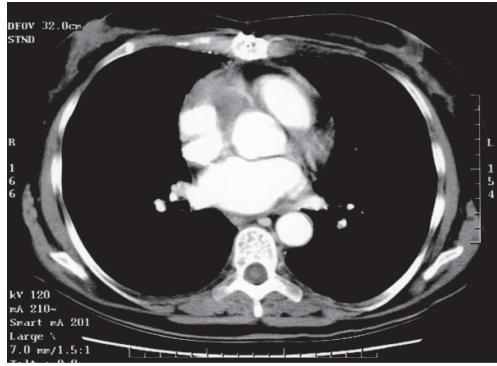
Cardiac mass on CT scan before chemotherapy.
